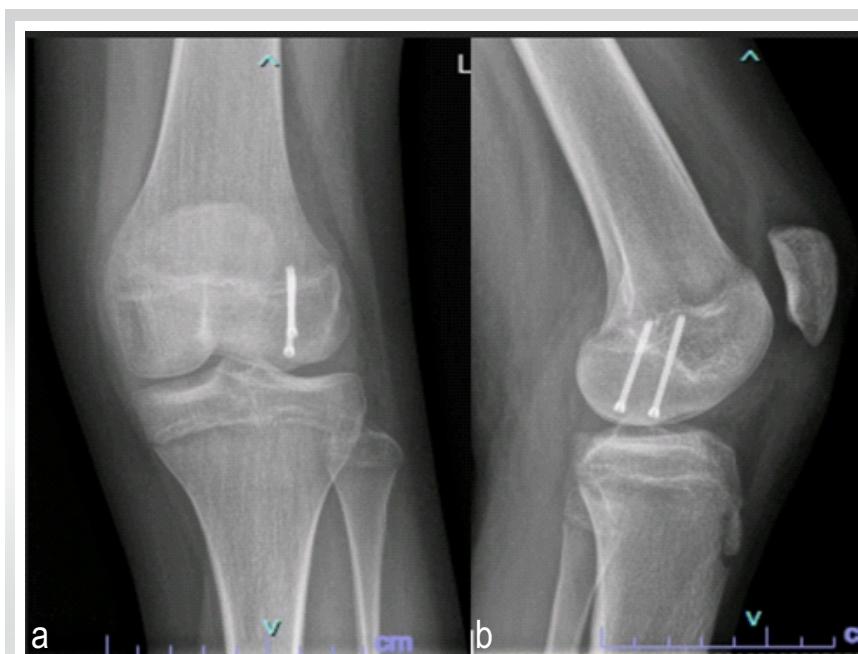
(a and b) Immediate post-operative radiograph; immediate post-operative anteroposterior (a) and lateral (b) radiograph confirming anatomical reduction and appropriate positioning of the fixation screws.
